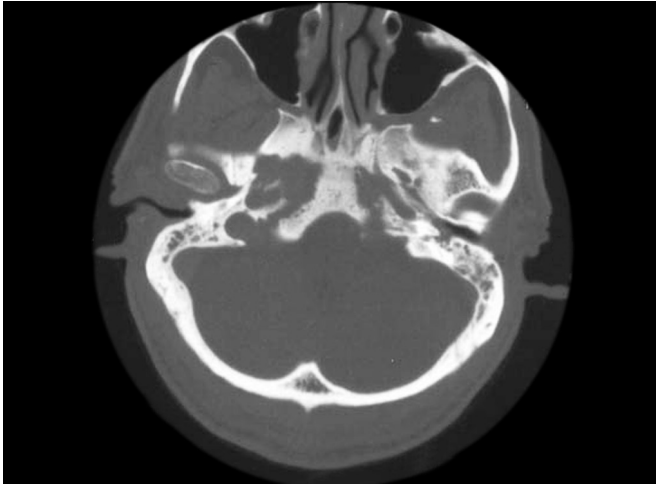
Axial high-resolution CT scan demonstrating skull base osteomyelitis with evidence of petroclival bone erosion.
